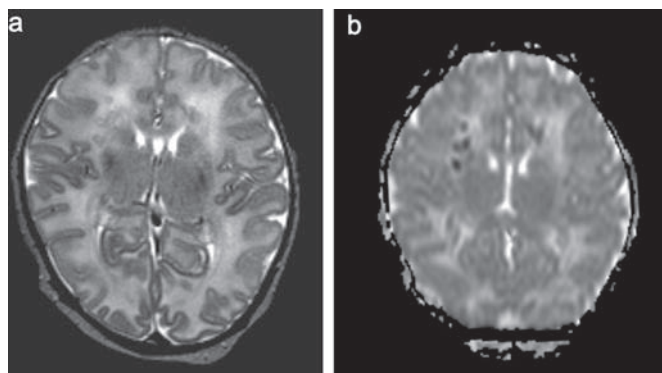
MRI on day 7 in an infant with punctate white matter lesions. (A) T2 weighted spin echo sequence image showing multiple Punctate white matter lesions (PWML) predominantly on the right side. (B) Apparent diffusion coefficient map showing the PWML as areas of restricted diffusion. Outcome at 3 years was within the normal range (DQ 96).
